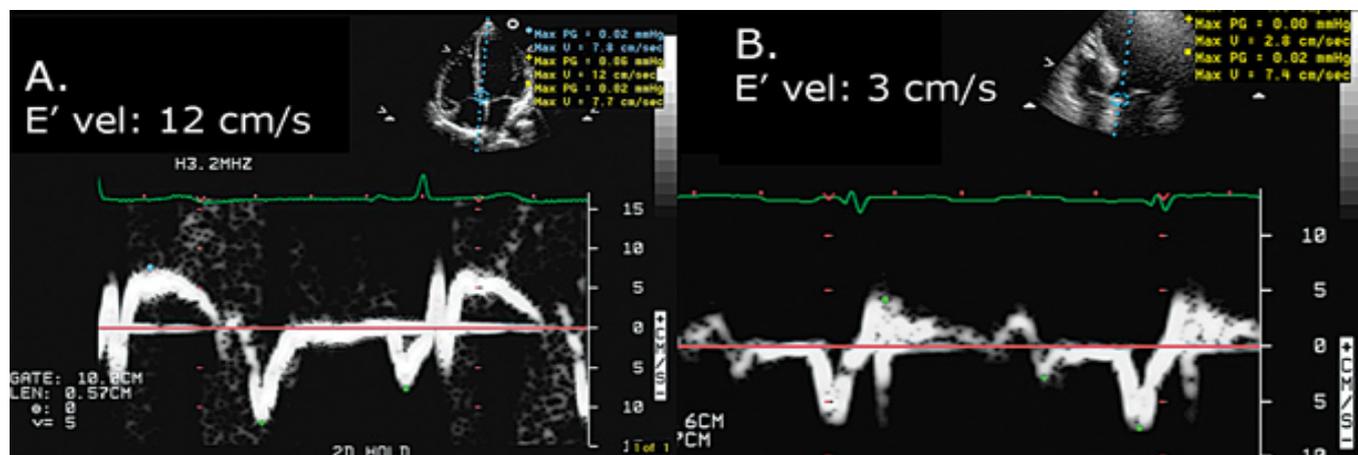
Tissue Doppler velocities at the level of the interventricular septum in apical four chamber view
